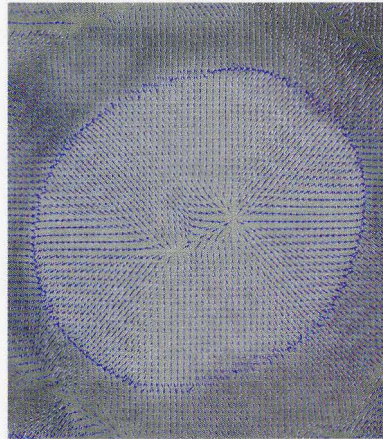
A typical GVF represented by a vector plot for a CT scan image. The boundary of the ROI of interest is clearly identifiable [27].
